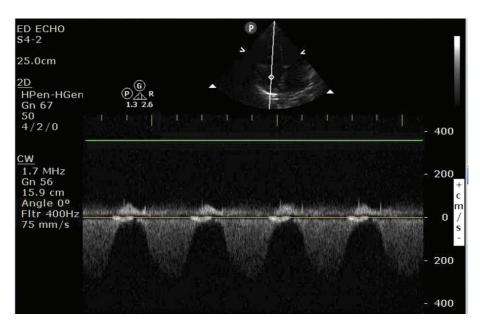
Right ventricular systolic pressure assessment using continuous wave Doppler.
